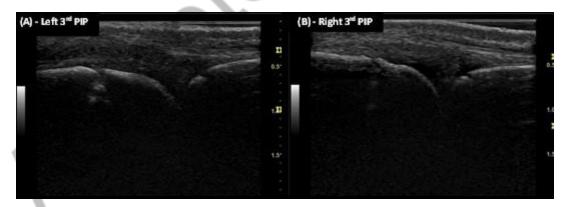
Hand ultrasound of the patient showing the third left (A) and right (B) proximal interphalangeal joints without evidence of synovitis or tenosynovitis.
